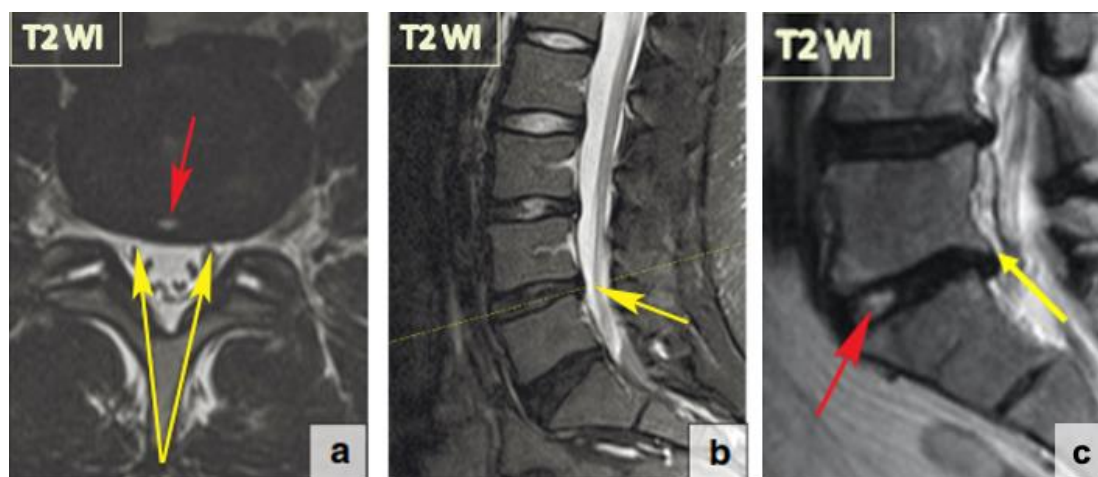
The results of MRI examination. (a) Transverse plane, T2WI sequence; (b) sagittal section, T2WI sequence. The protruding intervertebral discs are clearly indicated by the yellow arrows. Furthermore, the red arrow shows the hyperintensity in the posterior L4-L5 discs that is similar to the annulus fibrosus (Kushchayev et al., 2018). (c) Sagittal plane of T2WI sequence showing fluid-filled discs at L5-S1 (due to aging), and yellow arrows indicate osteophytes (Kushchayev et al., 2018).
